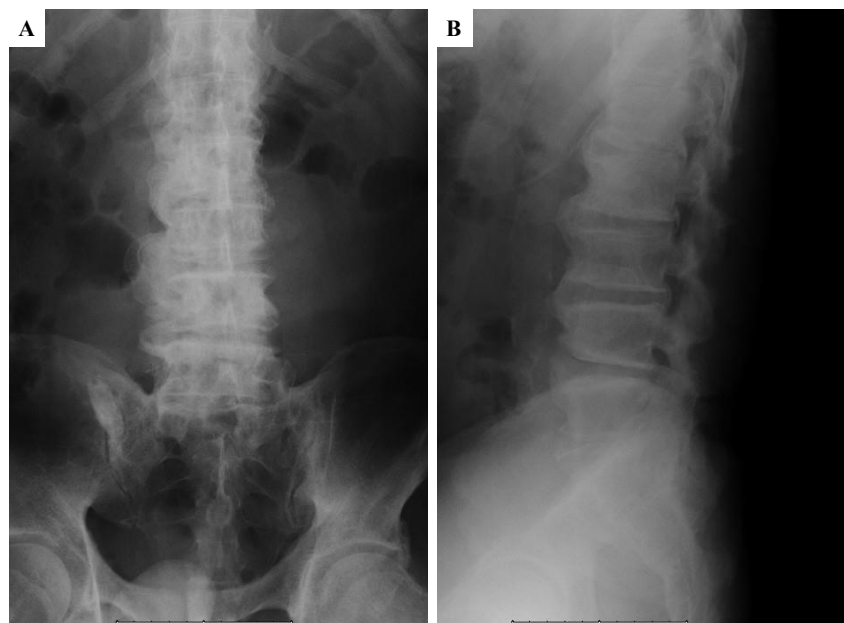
Plain radiograph of the lumbar spine (A: anterior and posterior views, B: lateral view). The radiographs show spondylosis of the lumbar spine.
